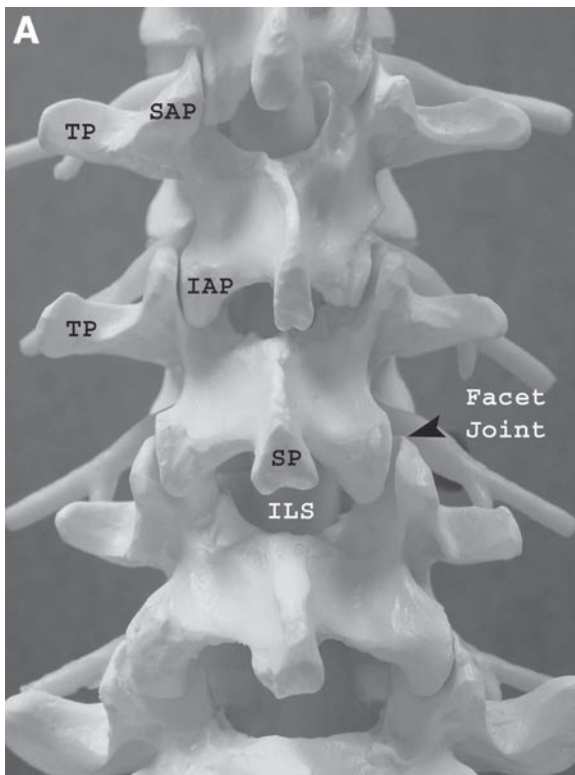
(A) Posterior view of spine. SAP, Superior articular process; IAP, inferior articular process; TP, transverse process; SP, spinous process; ILS, interlaminar space. (B) Axial CT through a lumbar vertebral body. VB, Vertebral body; P, pedicle; T, transverse process; L, lamina; S, spinous process. (C) Axial T2 MRI through a lumbar vertebral body. VB, Vertebral body; P, pedicle; T, transverse process; FJ, facet joint; SC, spinal canal.
